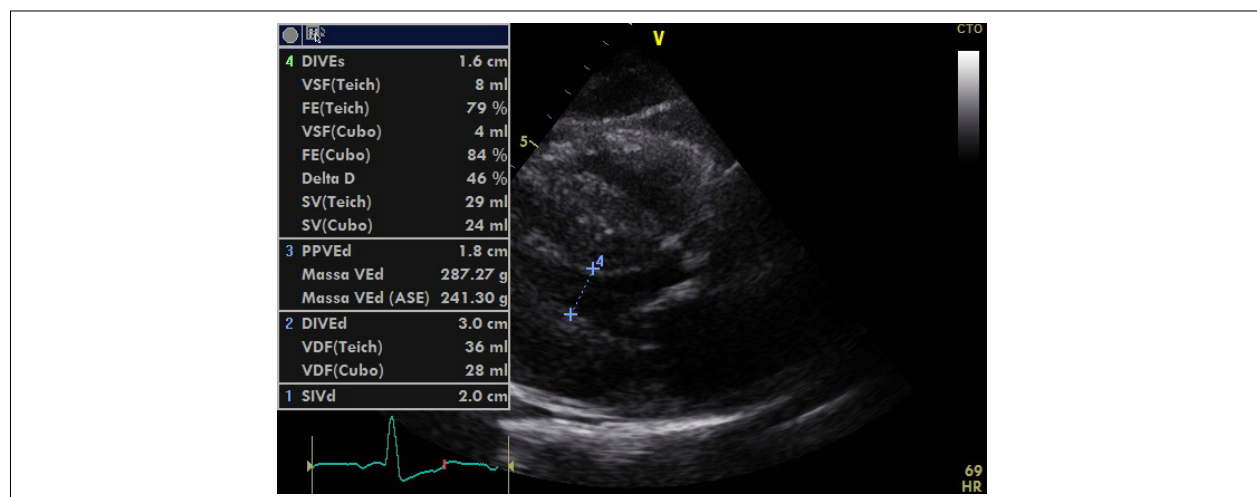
Parasternal longitudinal section on two-dimensional echocardiogram revealing significant increase in myocardial thickness in Case 1 patient.
